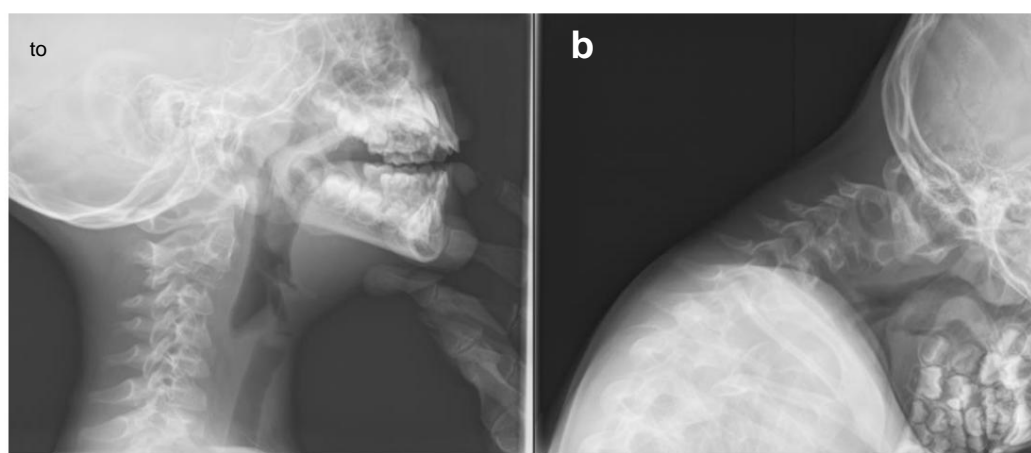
(a and b). Dynamic lateral radiographs of the cervical spine: a loss of height of the C3 vertebral body is observed, without added instability in flexion and extension. 72 73 74 75
